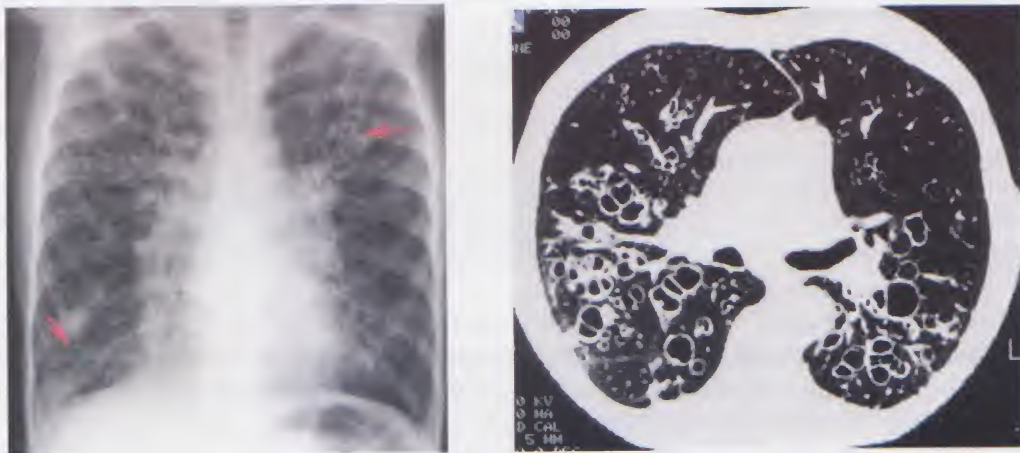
Plain chest x-ray (left) and CT scan (right) showing honey comb appearance of bronchiectasis
